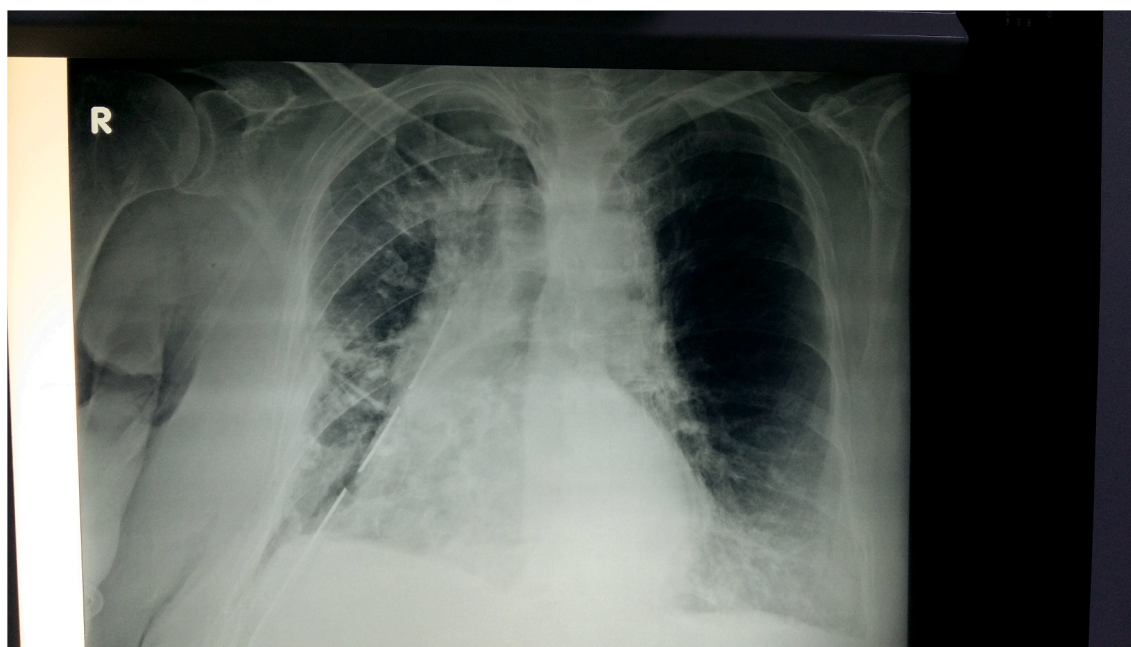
Chest x-ray with the chest tube inserted, the right lung has expanded.
